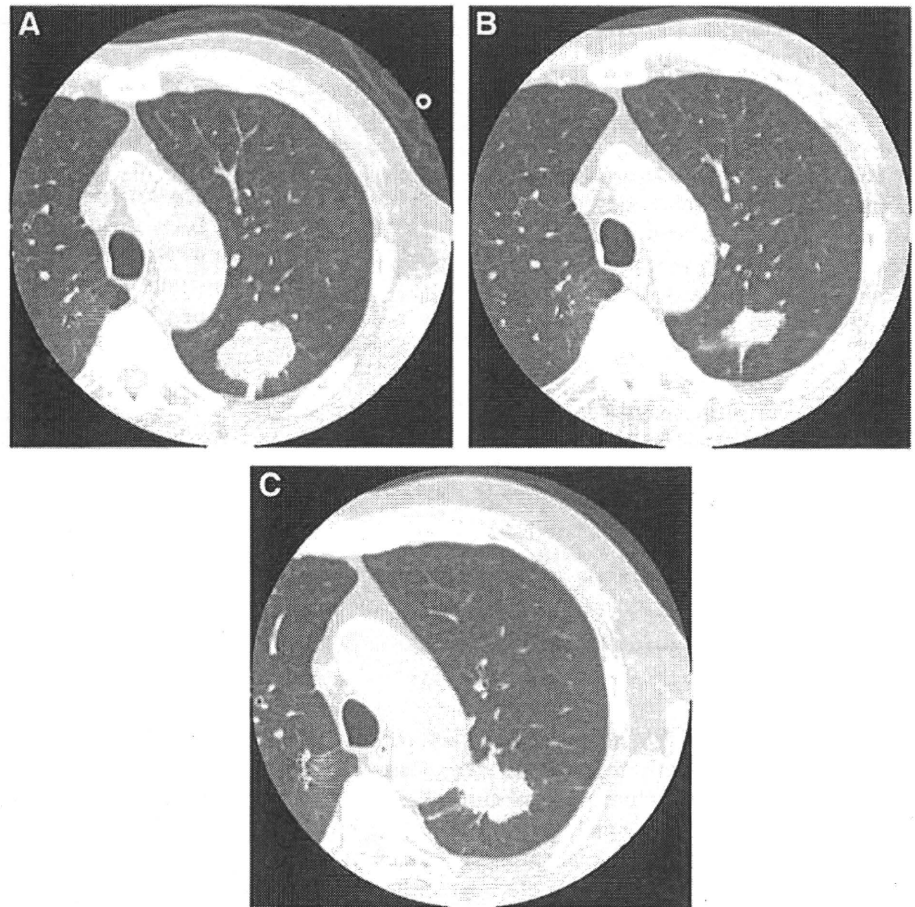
Clinical course of patient 1. A, Chest computed tomography (CT) at stereotactic body radiotherapy (SBRT) showed a mass with 36 mm in diameter in the left upper lobe. B, Chest CT 5 months after SBRT demonstrated remarkable tumor shrinkage. C, Chest CT 10 months after SBRT revealed an apparent tumor relapse.
